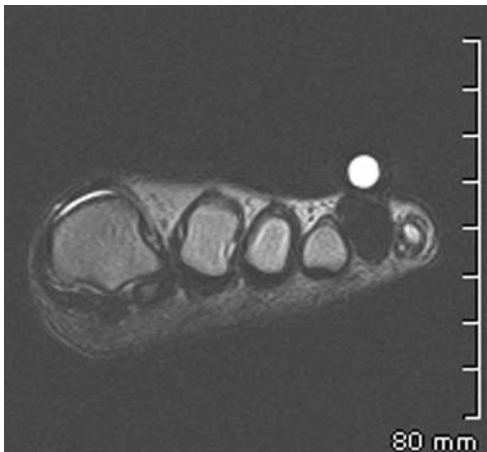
T2-weighted image demonstrating the hypointensity of a foreign body granuloma between the fourth and fifth metatarsal heads.
